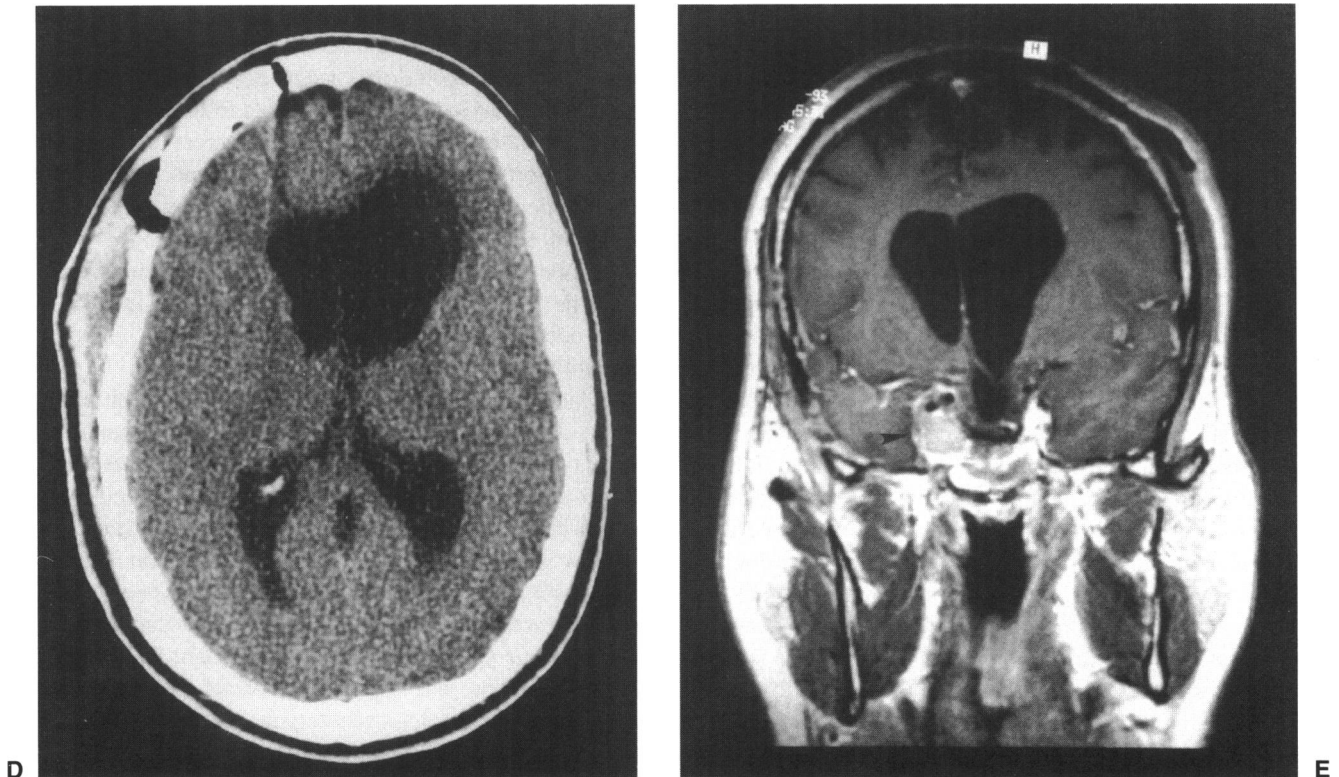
(Continued) D: After a subsequent craniotomy the residual tumor has been removed and the CSF fistula into the third ventricle has been repaired. A ventriculo-peritoneal shunt was subsequently placed. E: Postoperative MRI shows a near complete tumor resection. There is a remnant of tumor (arrow head) compressing, though not invading, the right cavernous sinus.
